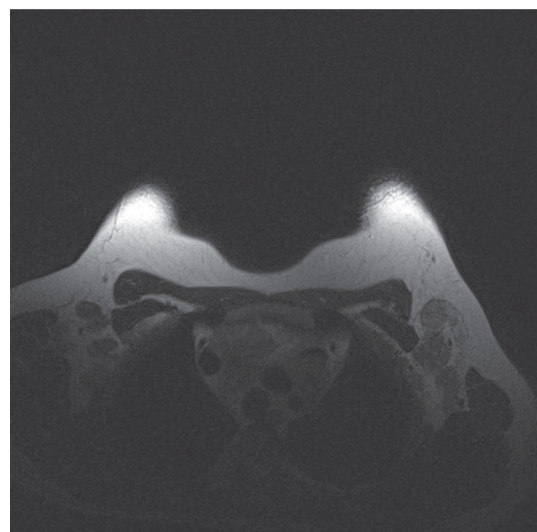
Breast MRI, axial T1 image, Multiple enlarged pathologic appearing lymphadenopathies are seen in both axillae
